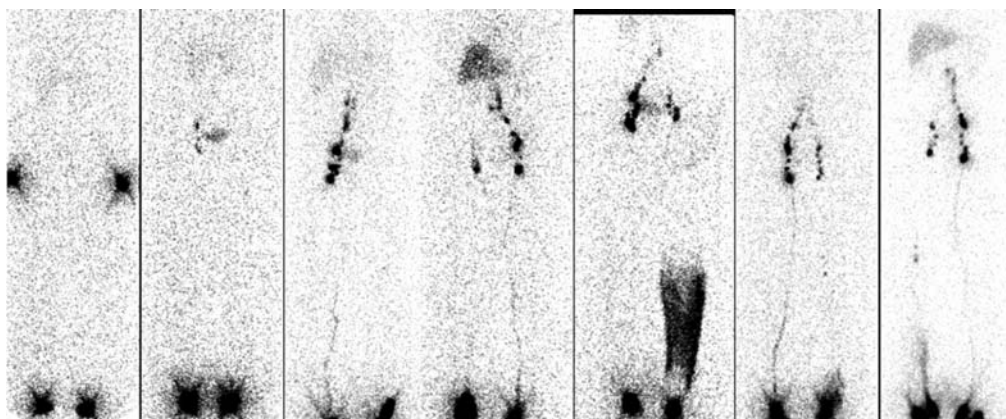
Variability of lymphatic capacity in primary LE: A set of lymphoscintigrams from seven individuals with primary LE. Lymphoscintigram on far left demonstrates almost complete absence of lymphatic nodal structures, but moving rightward, other individuals demonstrate sequentially greater lymphatic integrity. Study on far right demonstrates an asymmetric, but almost normal pattern.
